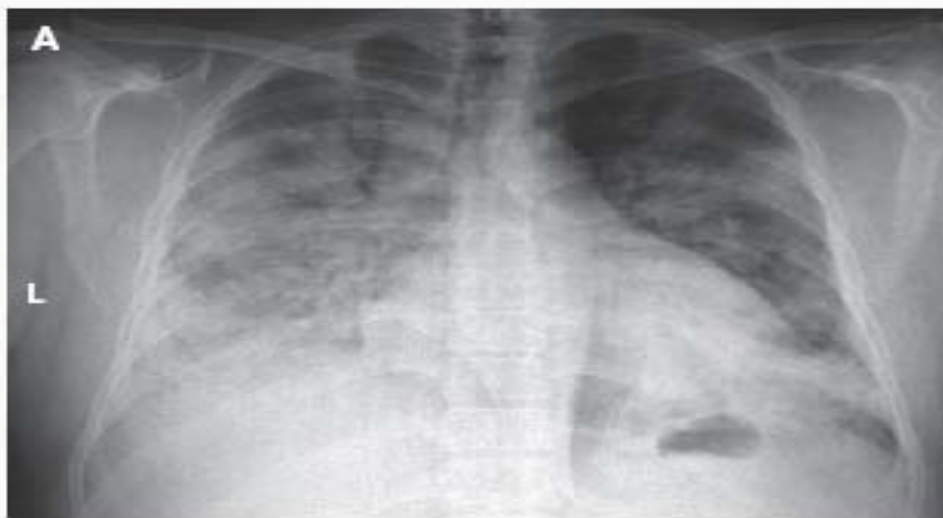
Initial Radiograph of the Lung and Lung-Tissue Sample from Patient 3.
